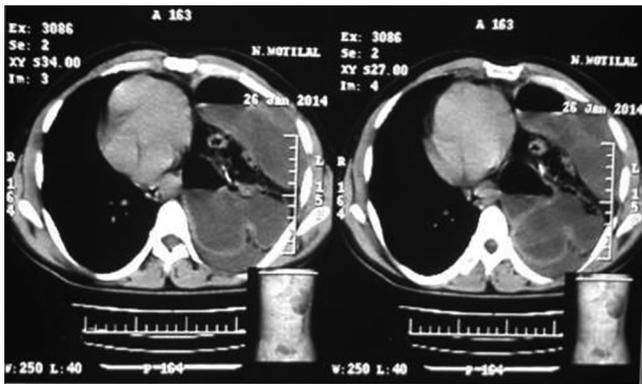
Axial section computed tomography thorax
